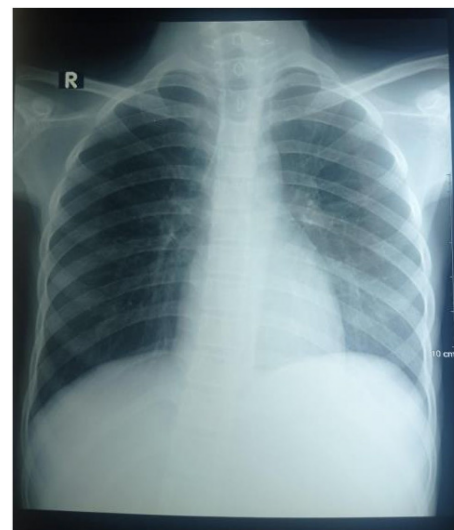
Chest x-ray showed normal finding
